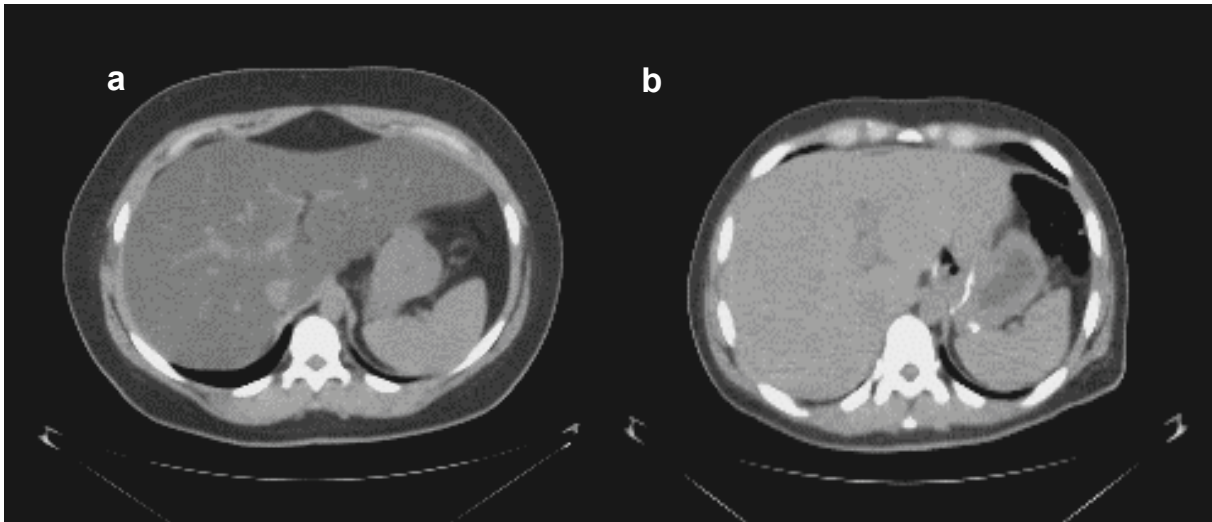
Figure 5a shows liver with elevated fat content. The mean CT number is -1 HU. Note that the vascular structures are detectable due to the lower density of the fatty liver relative to the vessels. Figure 5b shows the same patient after bariatric surgery. The CT number of liver tissue has increased to 53 HU.
